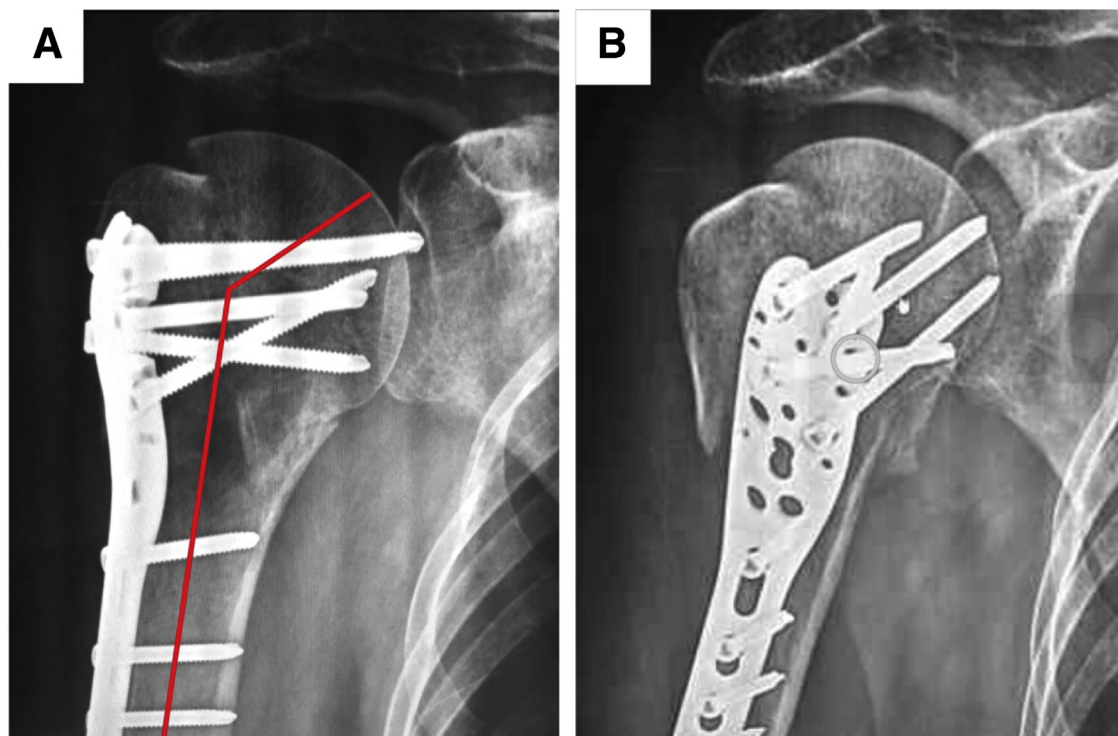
The case where screw penetration could not be detected intraoperatively is shown. A postoperative radiograph of right shoulder, AP view, revealed acceptable head-shaft angle but screw penetration was seen (A). The light bulb location is not centered and over the plate (B), therefore excessive retroversion should be suspected. Incorrect plate placement was observed with screw penetration anteriorly. (AP, anteroposterior.)
